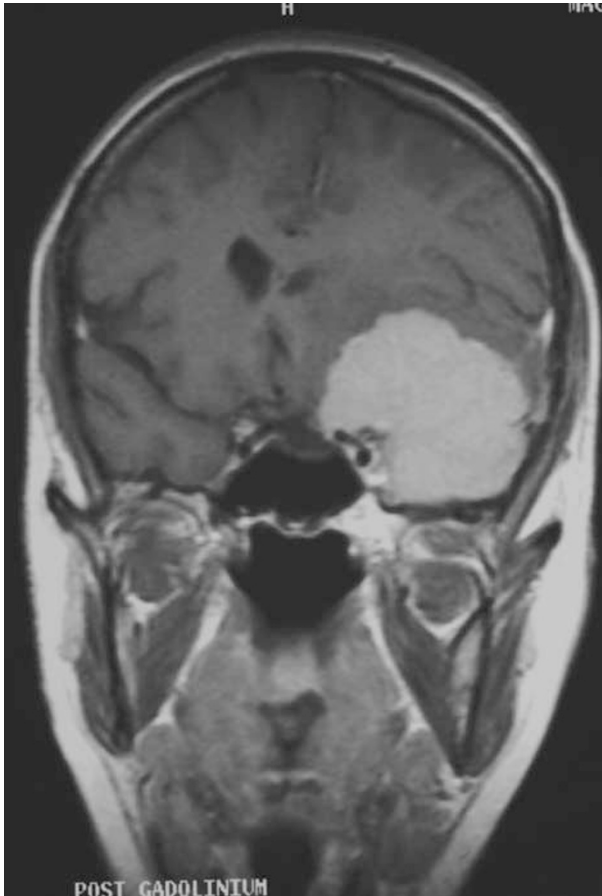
Gadolinium enhanced coronal MRI scan demonstrating large intracranial mass.
